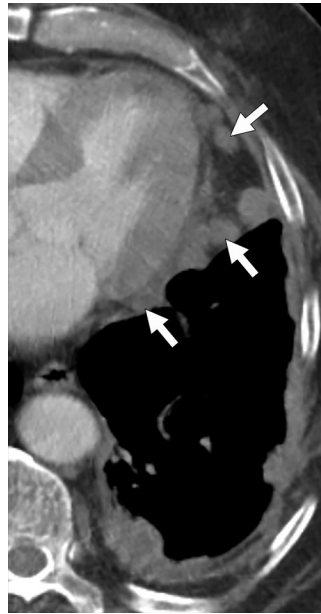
Lymphatic drainage of the anterior diaphragmatic pleura. Axial CT image shows anterior paracardiac and diaphragmatic lymph node metastases (arrows). Note the lobulated pleural thickening due to MPM.
